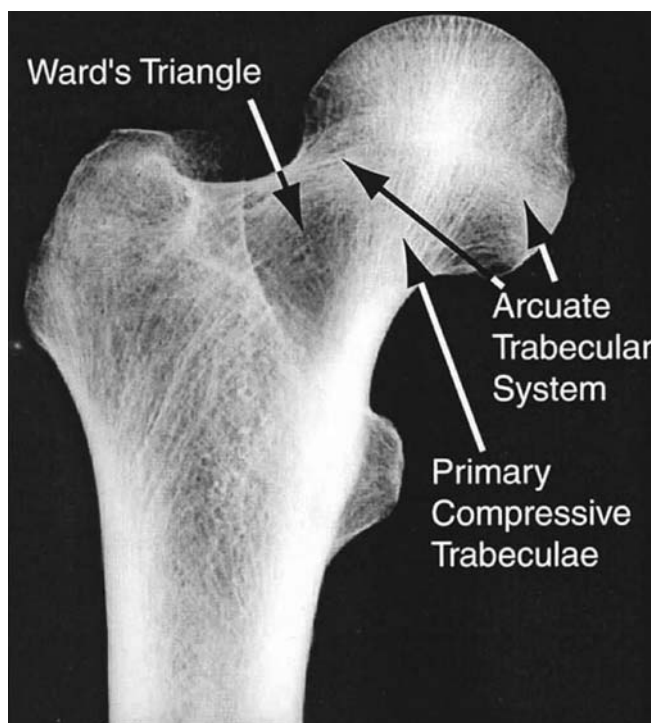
Radiographic frontal view of the proximal femur. Courtesy of Dennis Carter.
